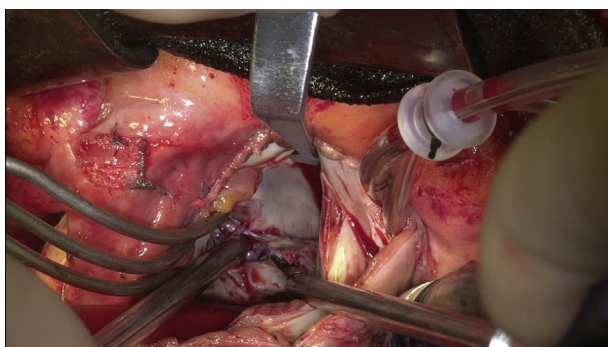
A, Preoperative echocardiography showing a malpositioned Watchman device in a 68-year-old man (case 2). B, Intraoperative photographs of the Watchman explant procedure. Approximately 50% of the device was protruding into the left atrium without associated thrombus. Although the device was completely endothelialized, it was successfully extracted without major injury to the left atrial appendage tissue. The orifice of the left atrial appendage was then closed with a running 4-0 Prolene suture in 2 layers. C, The explanted Watchman device was completely intact on removal.
